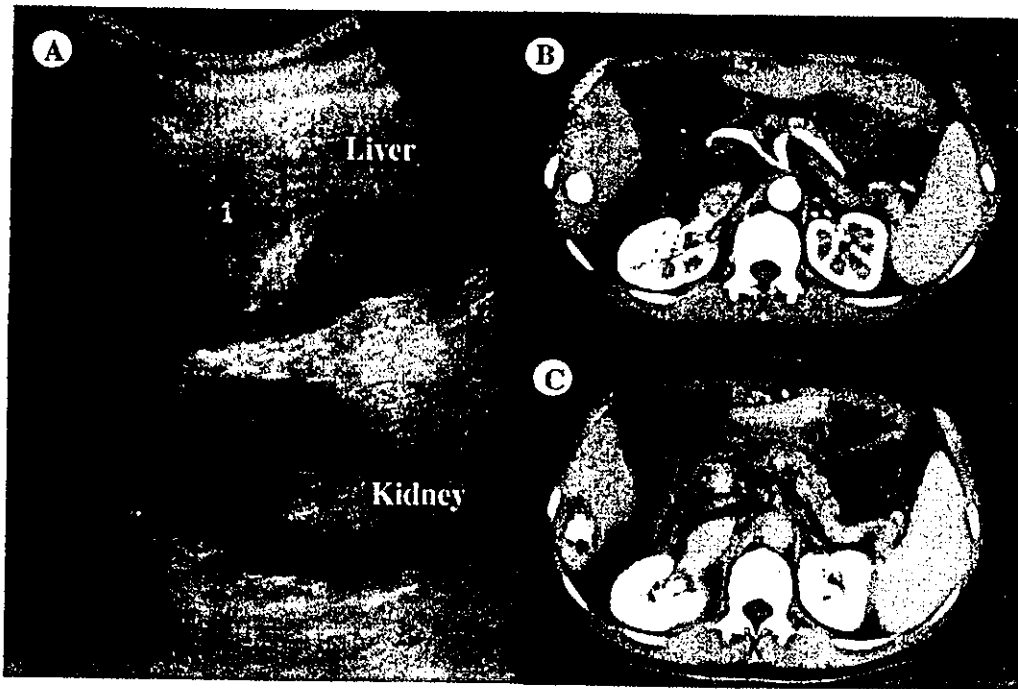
US image of HCC (2 cm) located in the S6 region close to right kidney (A). Contrast-enhanced dynamic CT before (B, early phase) and after (C, late phase) PELI-RFA is shown. The tumor showed clear early enhancement. PELI-RFA was performed at 70 W for 12 min after injecting 1.4 ml of the ethanol and lipiodol mixture. Although the amount of ethanol injected was small, accumulation of lipiodol was observed in the entire tumor and it was surrounded by the low-density area.
